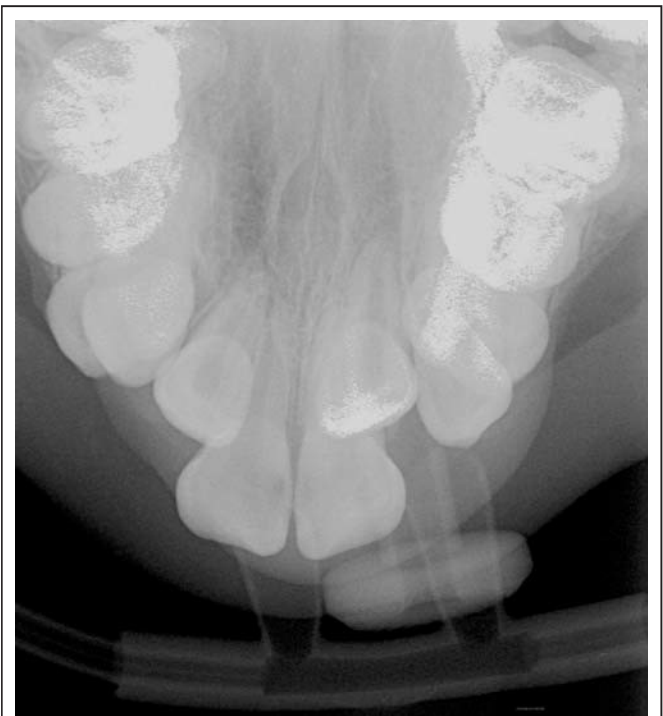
The anterior occlusal radiograph had a more grainy image than would be given by a dental X-ray machine operating at 70kV. The mobile theatre X-ray machine did not have a variable timer, so exposure was compensated for by reducing to 60kV
